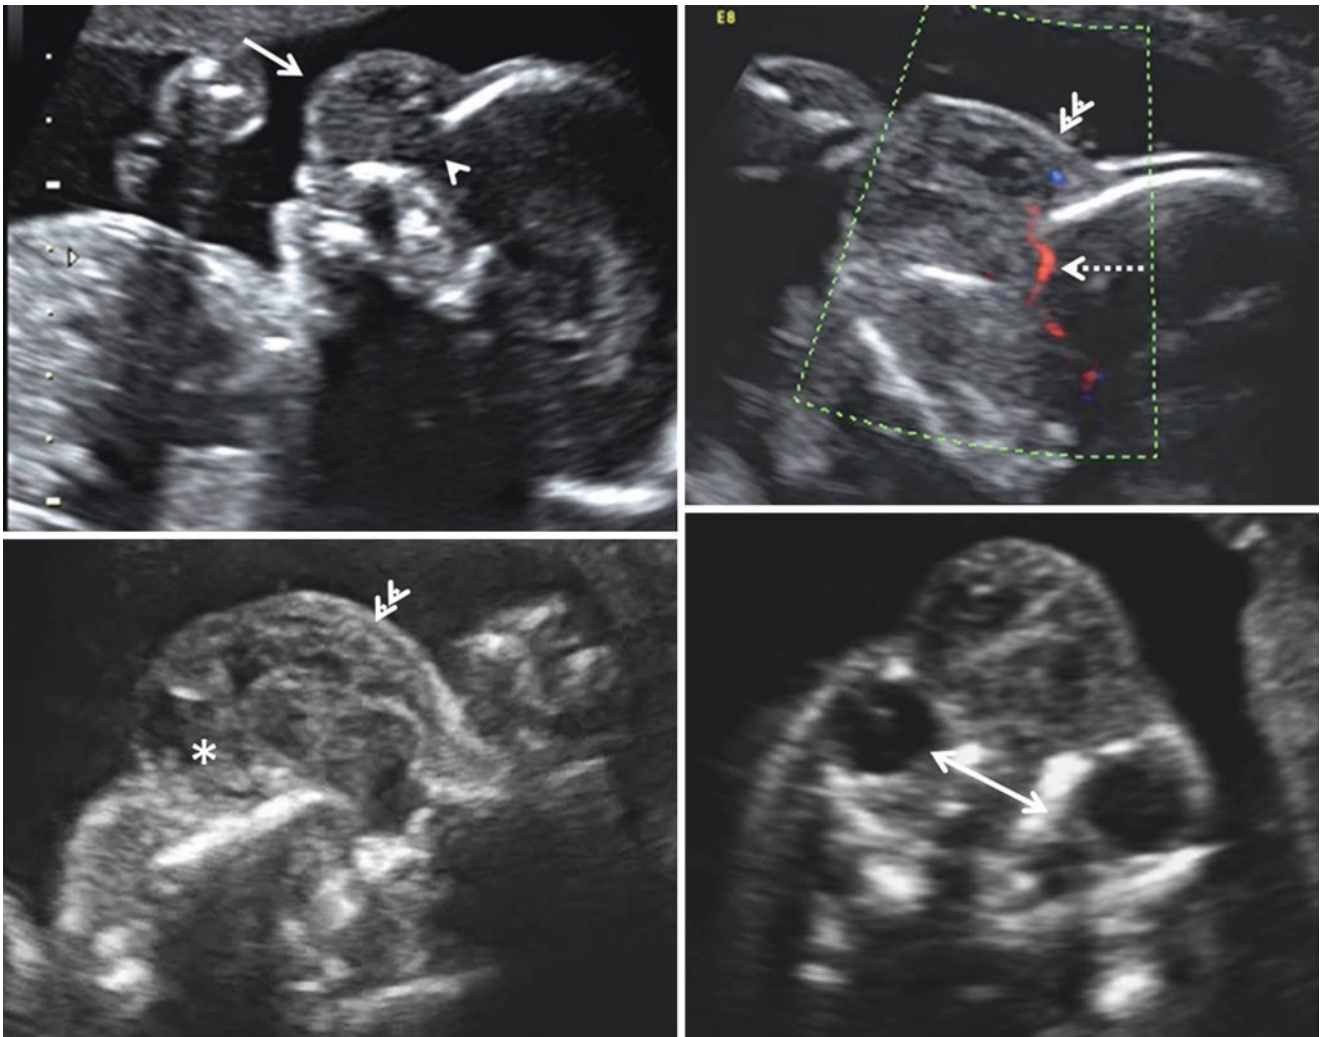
20 weeks (TAS) *frontal encephalocele* – midsagittal sections of fetal face B mode and color Doppler, magnified axial section of the lesion, axial section of the orbits – defect in the frontal bone (arrowhead), overlying soft tissue mass (solid arrow), intracranial artery
